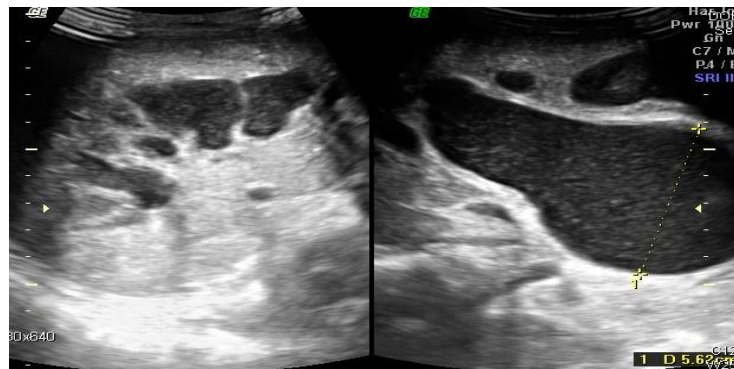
Ultrasound in another patient showing cystic dilations of IHBR as well as extrahepatic biliary system (type IV choledochal cyst)
